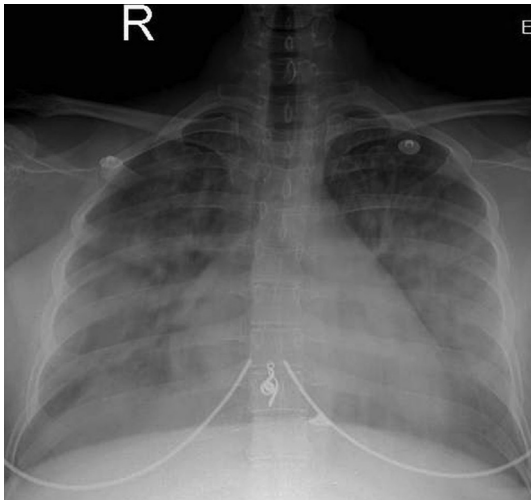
Chest X-ray showed cardiomegaly and increased reticular densities in the lower and middle zones bilaterally.
